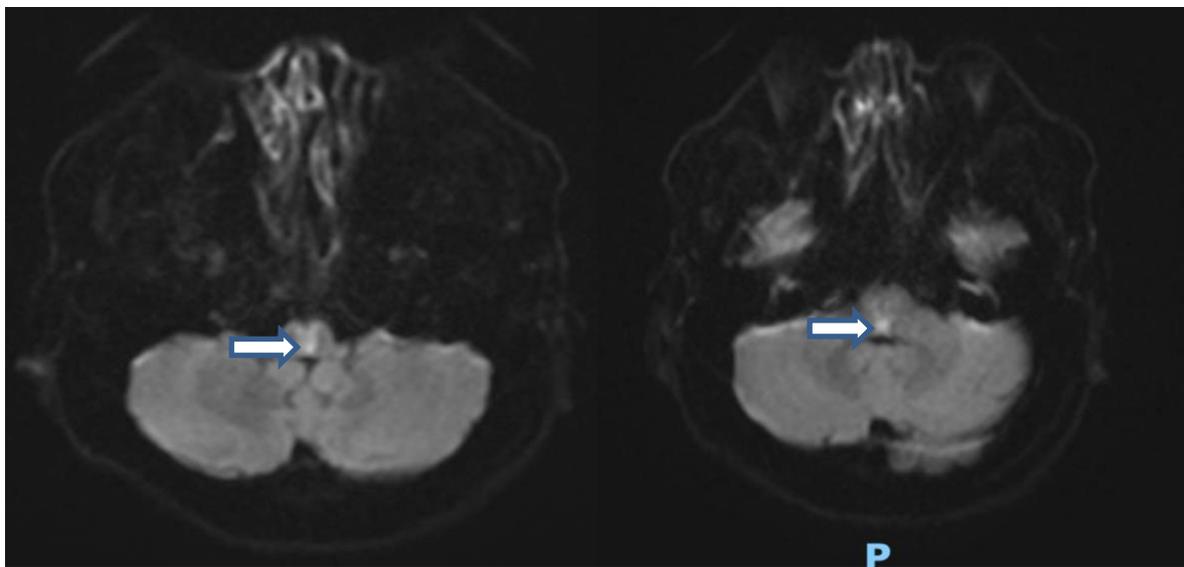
A V-shaped hyperintense lesion on diffusion weighted imaging (DWI) in the bilateral medial medulla extending up to the dorsal aspect of the caudal pons
